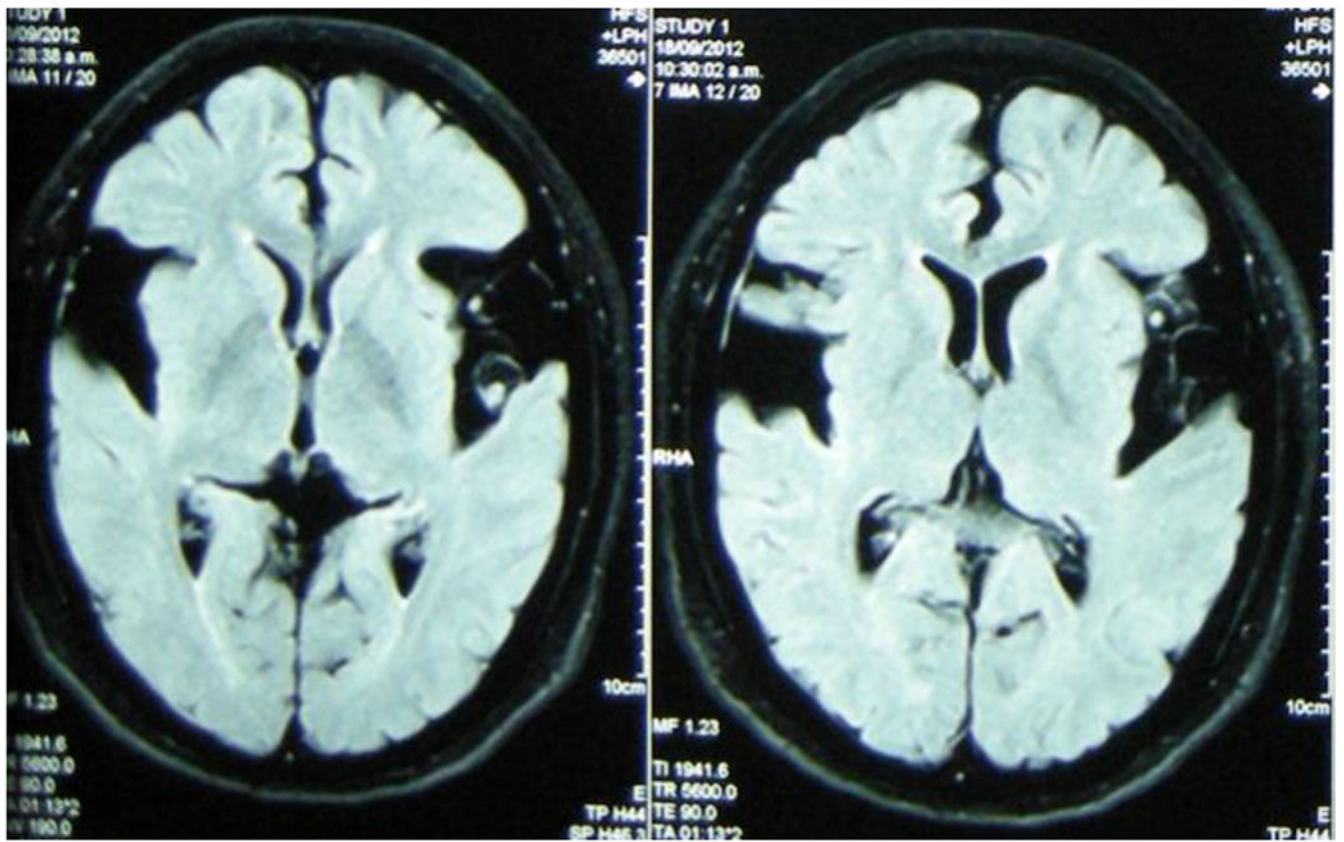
NCC cysts in contact with the subarachnoid space at the Sylvian cisterns, with visible scolices (non-contrast MRI, FLAIR protocol).
